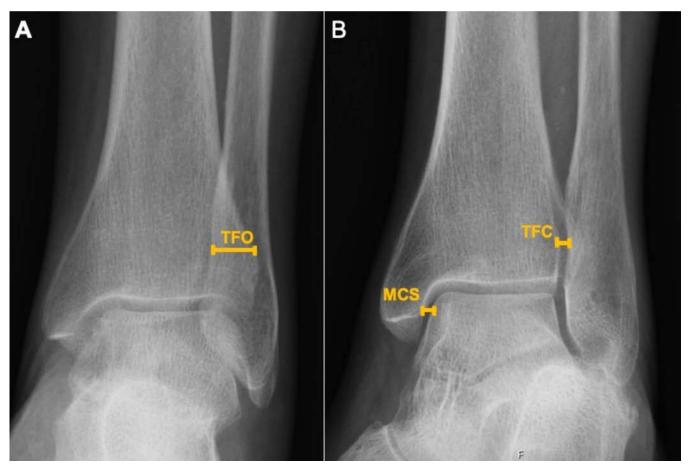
Radiographic parameters of the ankle associated with the syndesmosis. (A) Tibiofibular overlap (TFO); (B) Tibiofibular clear space (TFC) and medial clear space (MCS).
